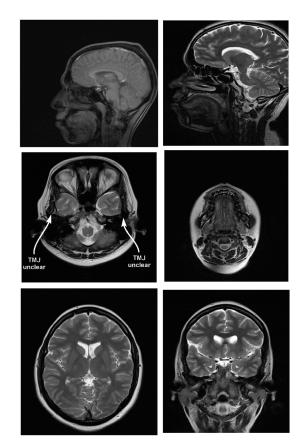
Magnetic resonance imaging (MRI) scans of the head and neck region with an Ortho-Direct titanium retainer in the mandibular arch
